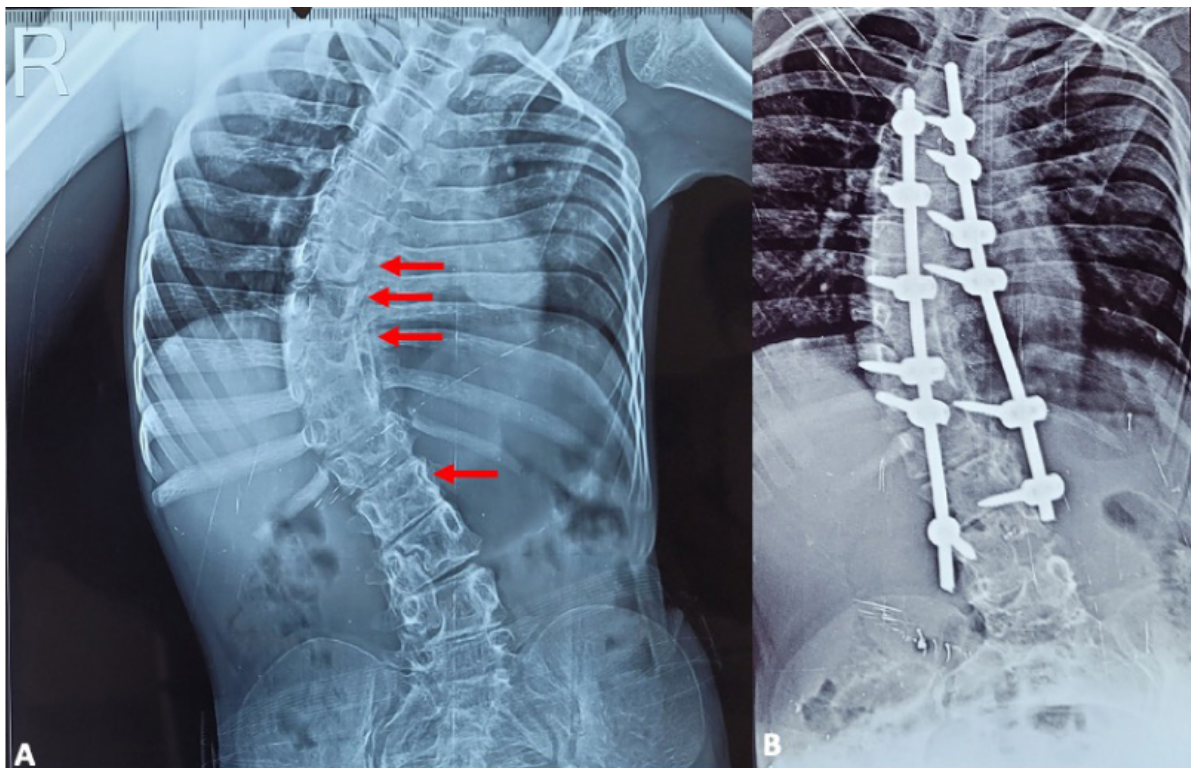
(A) Preoperative AP X-ray showing small hypoplastic pedicles (red arrows) at multiple levels on the concave side of the scoliotic deformity. Placement of PPSI is a contraindication in these cases and the patient underwent open pedicle screw fixation and correction of the deformity (B).
